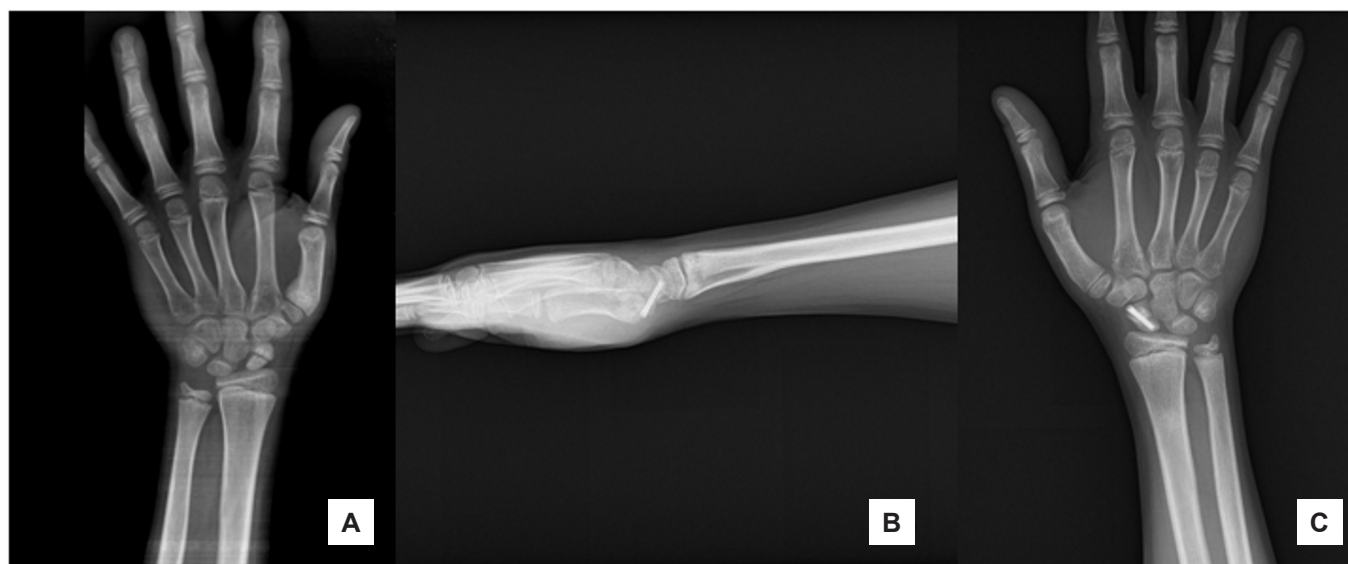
(A) Pre-operative x-ray of a 12-year-old male patient (Case 2) (B) Lateral x-ray at 1 year postoperatively (C) Posterior-anterior x-ray at 1 year postoperatively.
